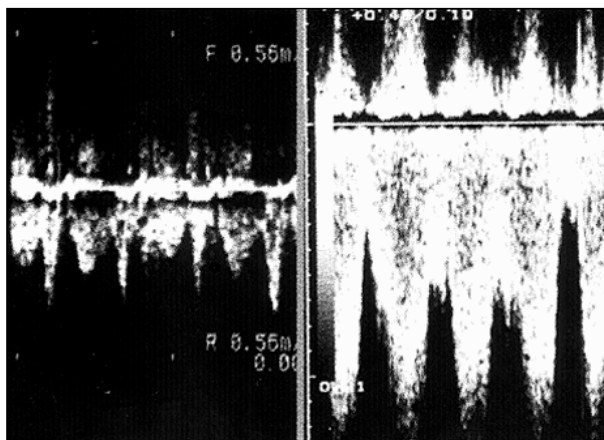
Echocardiographic data of the pulsed Doppler assessment: A) flow obtained in a healthy subject showing signs of low amplitude with good definition of the systolic and diastolic flows; B) flow obtained in a patient with persistent ductus arteriosus and atrial septal defect (patient 6) showing a continuous high-velocity flow.
